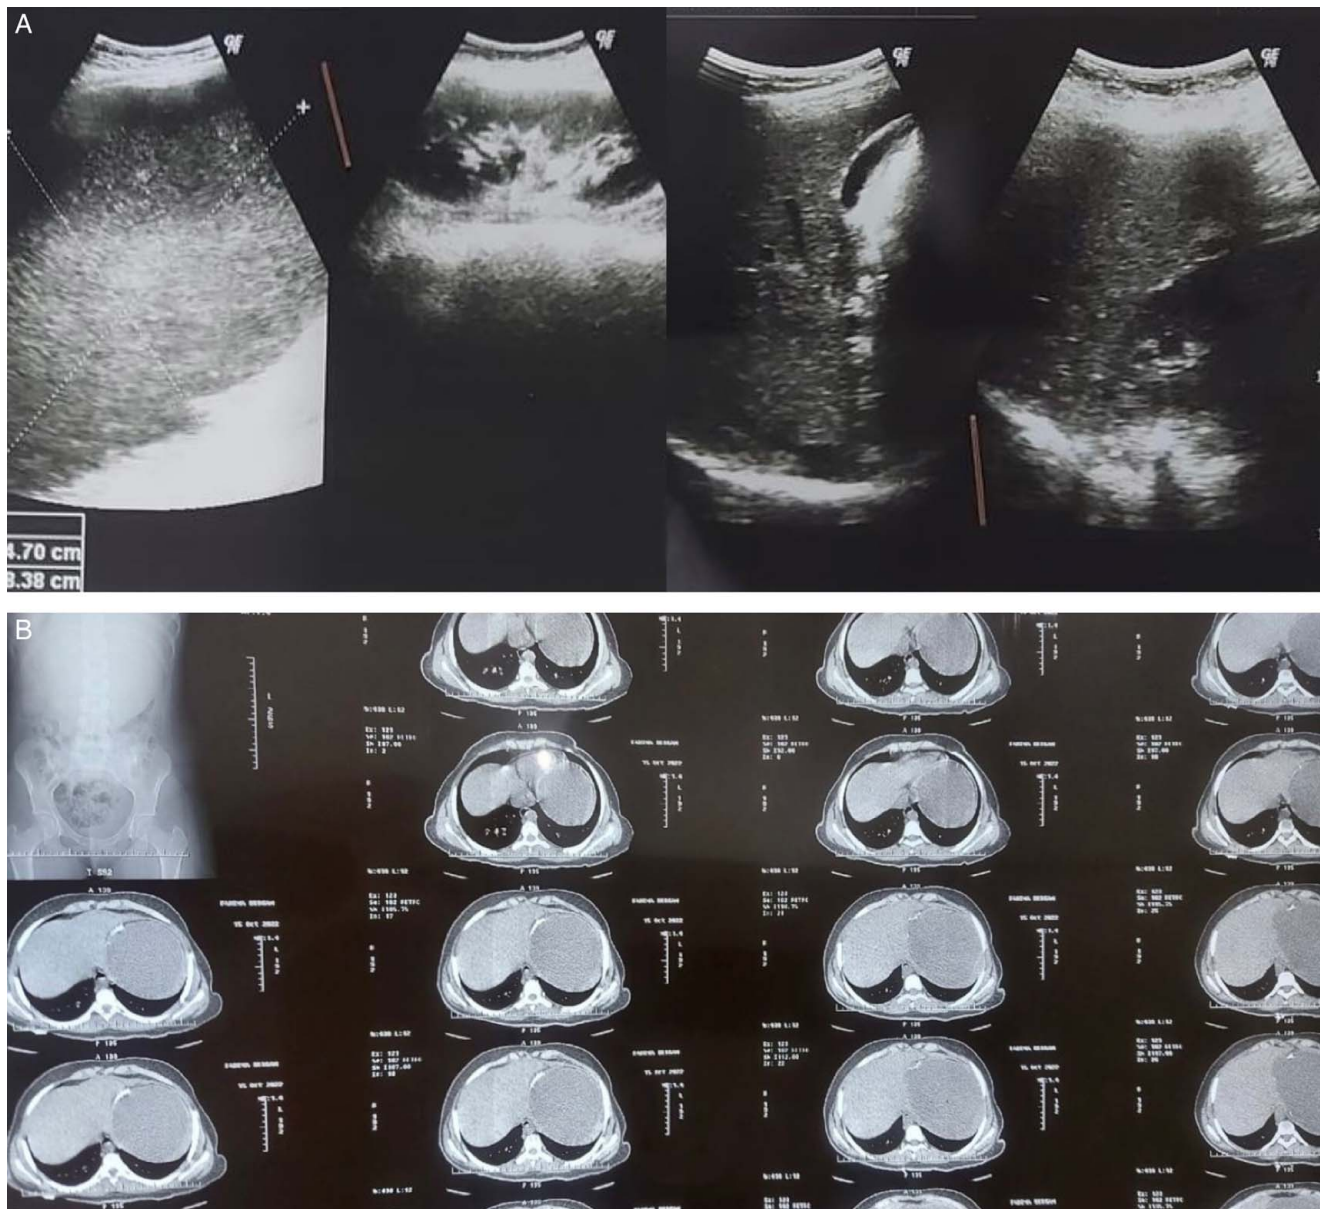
(A) Echography of the abdomen shows a giant lesion with pure fluids, the origin of the lesion is unrecognizable in this echography. (B) Axial images of an enhanced computed tomography scan of the abdomen show a large 25 × 16 cm, well-defined hypodense cystic mass of the spleen.
